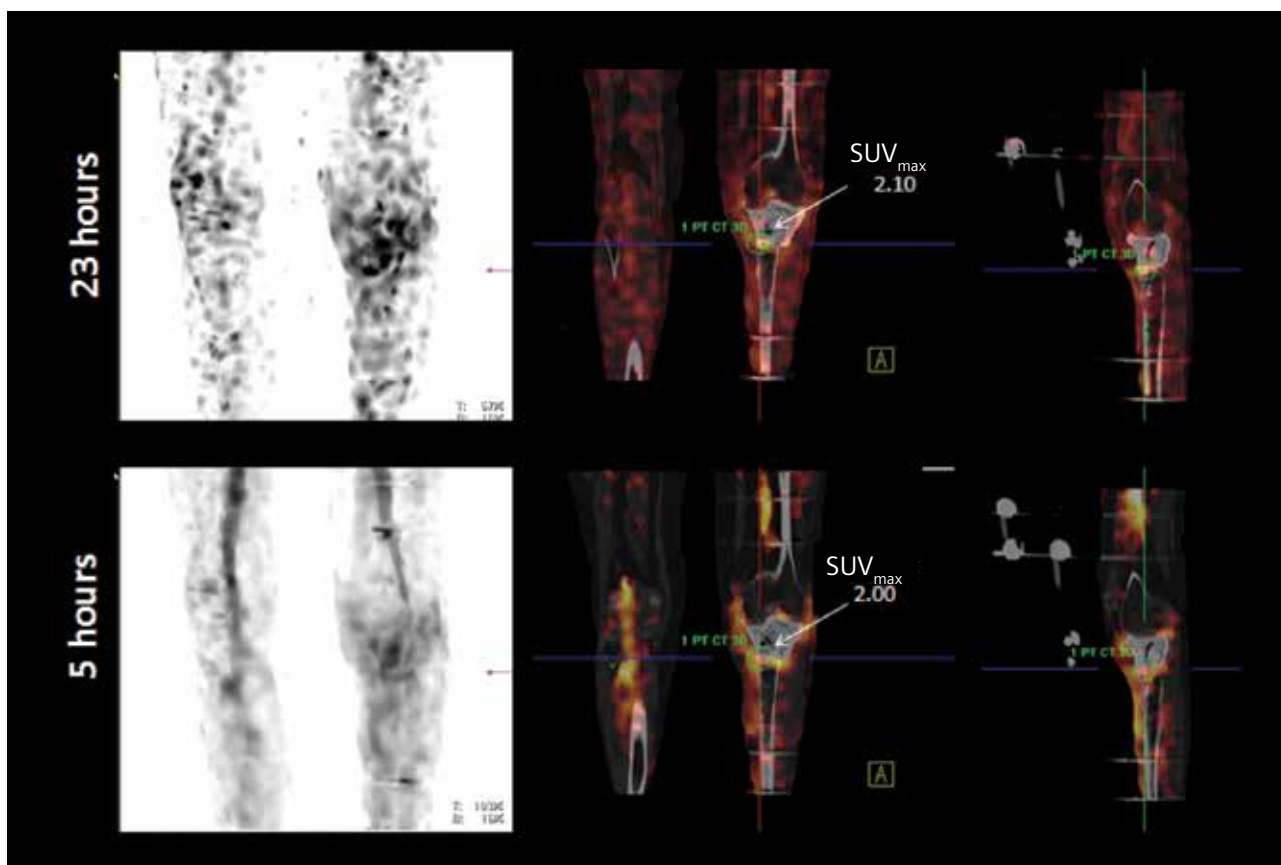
MIP of SPECT and fused images of the sequential 5- and 23-hour SPECT/CT study show slight increase in uptake in the zone separating the cement spacer occupying the region of the proximal tibia and the tibial shaft, with an  $SUV_{max}$  of 2.00 in the 5-hour study which remains relatively unchanged to 2.10 at 23 hours, suggesting an absence of active infective foci.
